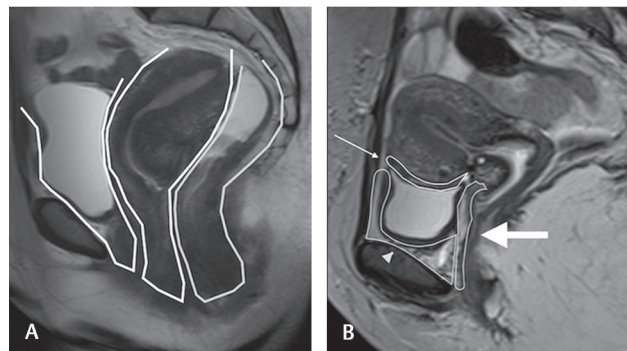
(A, B) Sag T2W image (A) showing the anterior, middle, and posterior compartments and (B) T2W sag image showing the pre-vesical space (*arrowhead*). Vesicouterine pouch (*thin arrow*) and the vesico-vaginal septum (*solid arrow*). T2W, T2-weighted.
